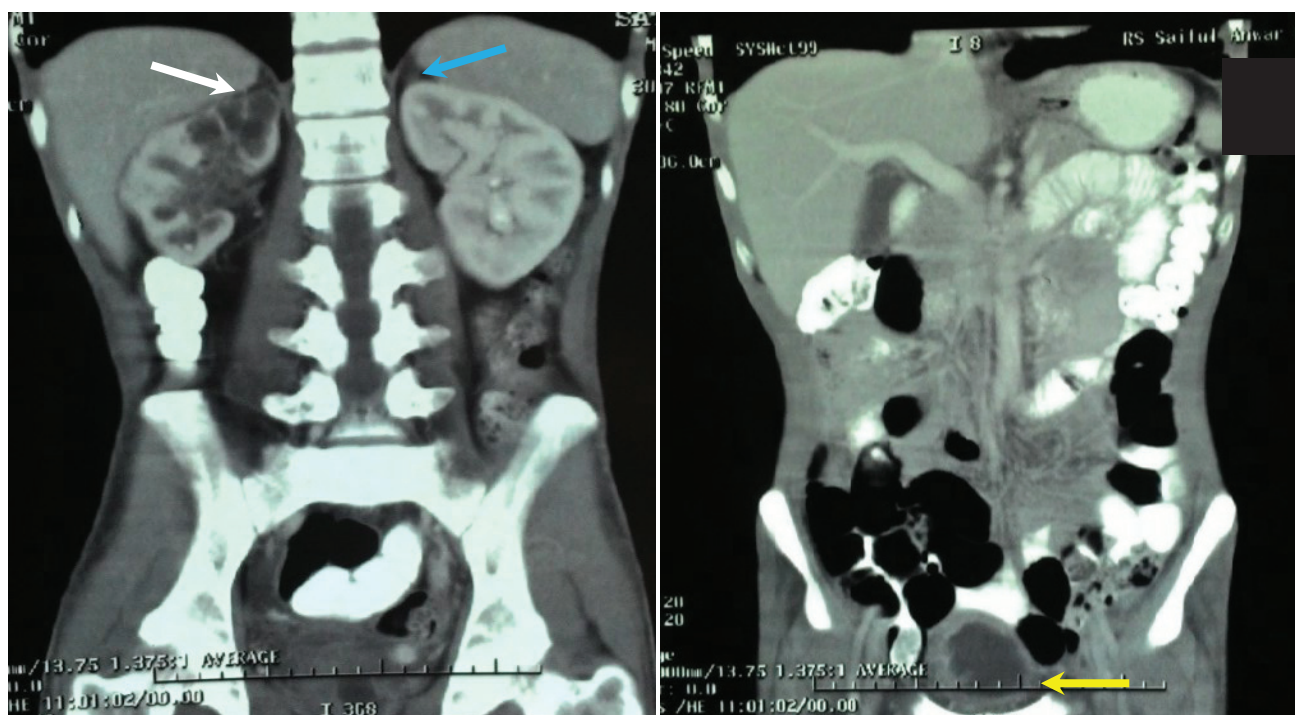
CT scan of the abdomen on coronal view showed a right adrenal gland measuring 3.3 cm x 2.6 cm with multiple cysts (*white arrow*), a hypoplastic left adrenal gland measuring 1.4 cm x 0.9 cm (normal value 4 cm x 2 cm) (*blue arrow*), right hydronephrosis grade III to IV, left hydronephrosis grade II, chronic ureteritis and cystitis (*yellow arrow*).
